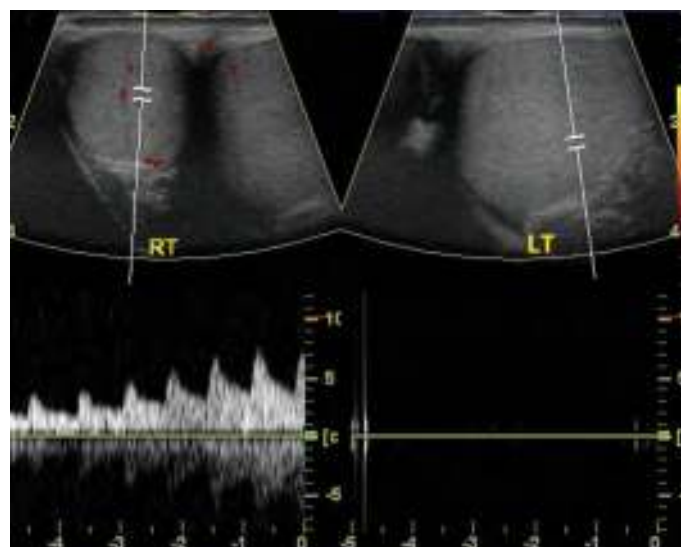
Color spectral Doppler US image showing the normal arterial flow in the right testicle (left side of picture) and no flow in the left testicle (right side of picture). (Photo used with permission from www.iame.com.)
